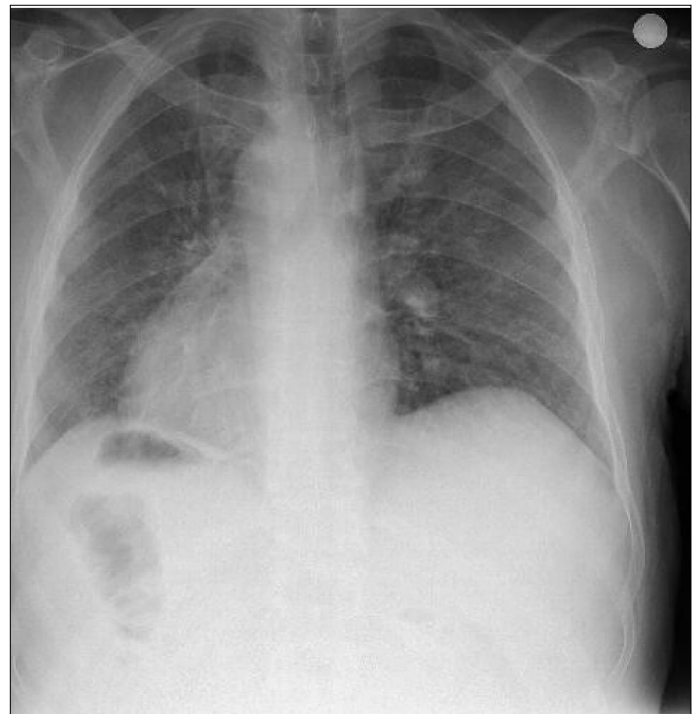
Chest X-rays showing resolution before discharge.
